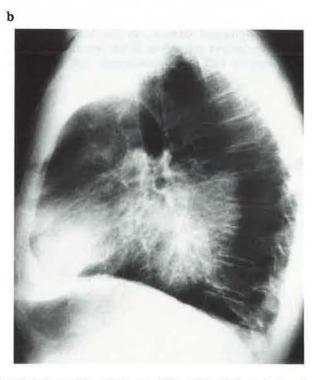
a) Postero anterior (PA) chest roentgenogram. The lateral border of the descending aorta is not visible, within the heart shadow the contours of a mass are seen. b) Lateral roentgenogram: a large mass is present behind the heart.
